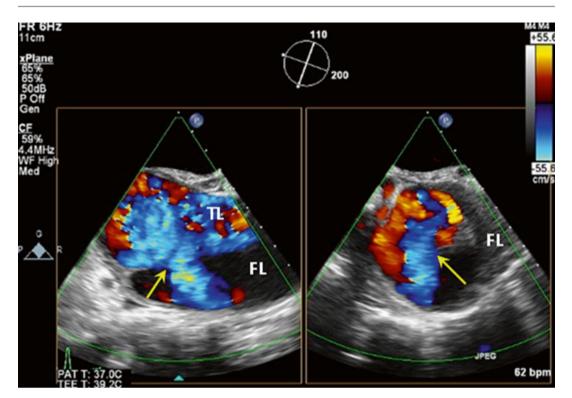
2D TEE color Doppler, x-plane view, showed blood flow from the true lumen (TL) to the false lumen (FL) through the initial flap tear (arrow)
